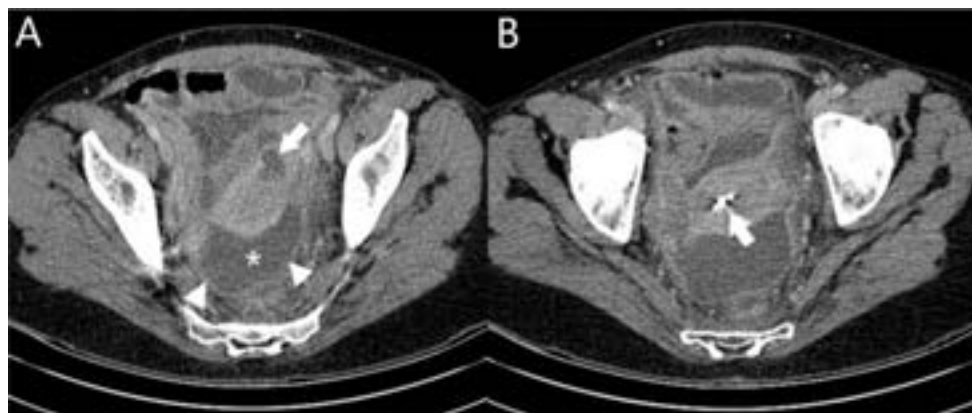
A) Axial slice of a pelvic CT after IV contrast that shows fluid (asterisk), peritoneal enhancement (arrowhead) and a tuboovarian abscess on the left (arrow). B) Lower slice shows IUD (arrow).
